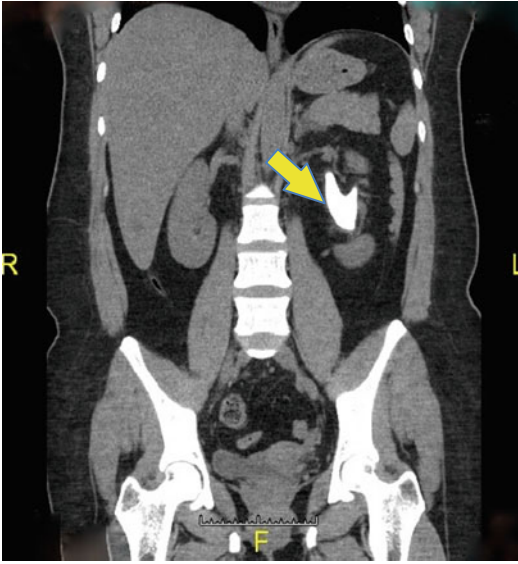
Coronal CT scan image demonstrating a stag-horn calculus (yellow arrow) occupying much of the left renal pelvis
